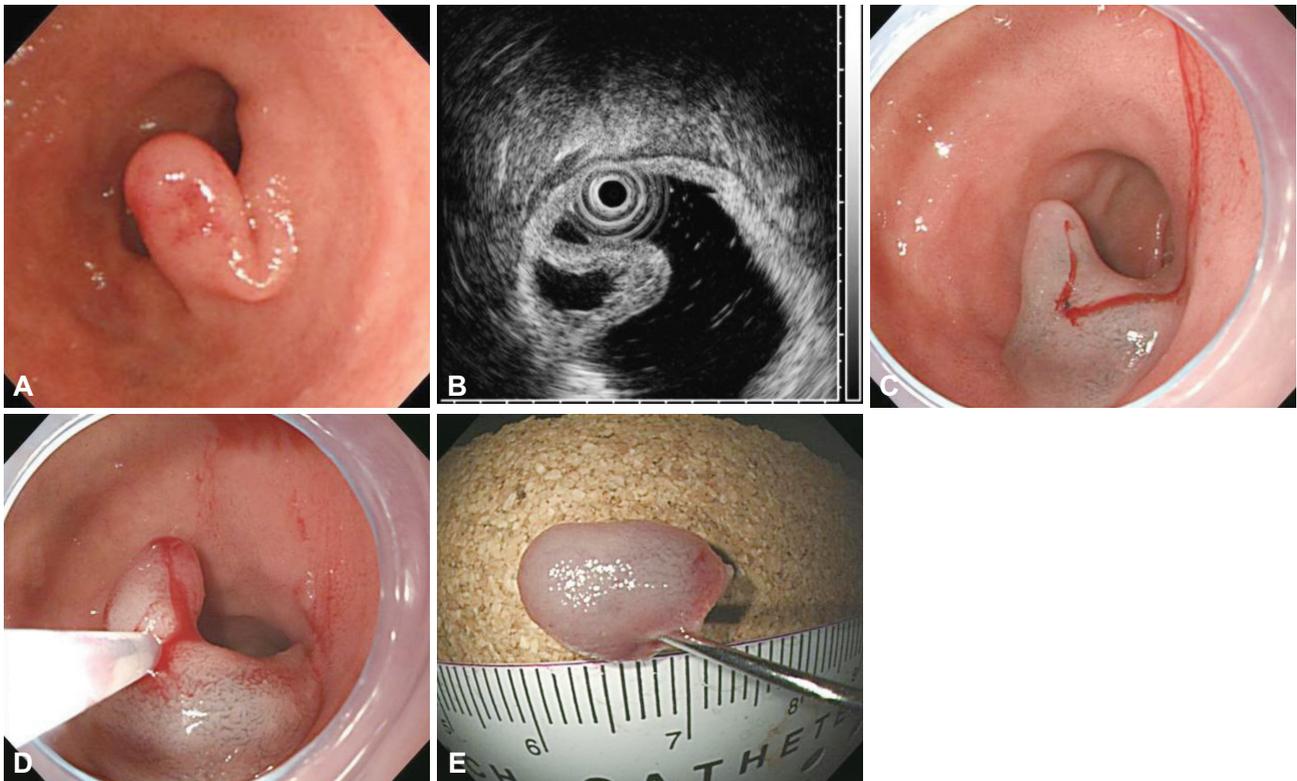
Endoscopic mucosal resection of the duodenal duplication cyst. (A) A polypoid lesion at the posterior side of superior duodenal angle. (B) Endoscopic ultrasonography shows an anechoic homogenous, oval lesion originating from the submucosal layer of the duodenum wall; the wall of the cystic lesion is shown as a three-layer structure. (C) Injection of saline with indigo carmine into the submucosa. (D) After the submucosal injection, the snare is closed to capture the lesion. The lesion is then resected with a standard snare excision technique. (E) The lesion is completely removed.
